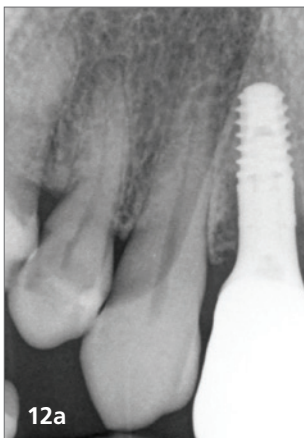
Try-in of the custom CAD/CAM abutments. Fig. 11: Inserted fixed partial denture with customised gingival profile. Figs. 12a & b: Control radiograph after insertion of the fixed partial denture made of ZrO₂ ceramics. Fig. 13: Harmonious profile of the upper lip following the rehabilitation of the dental arch with an implant-supported fixed partial denture.
